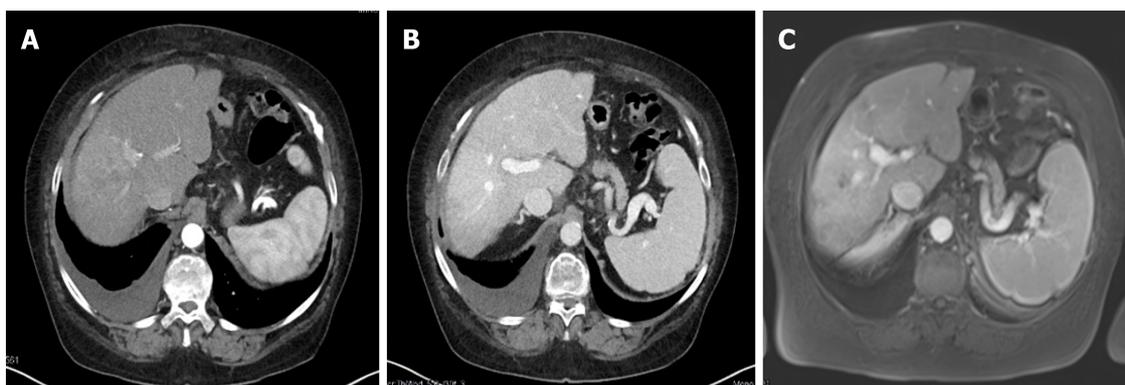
Complete response 9 months after transarterial chemoembolization and stereotactic body radiation therapy. A: Contrast-enhanced computed tomography (CT) arterial phase; B: Contrast-enhanced CT venous phase; C: Magnetic resonance imaging with liver-specific contrast agent.
